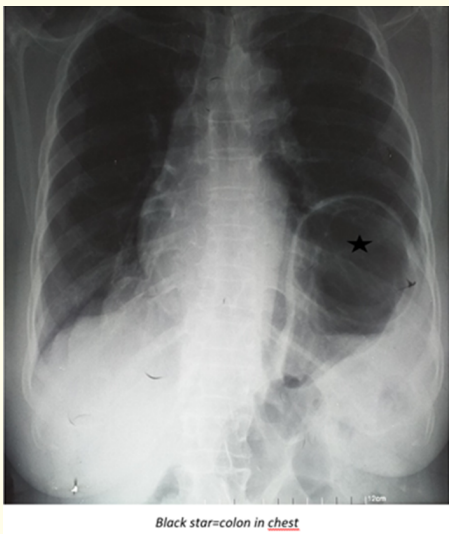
Frontal chest X-ray showing the ascent of the left diaphragmatic dome and the presence of digestive gas intrathoracically in our patient 1.
